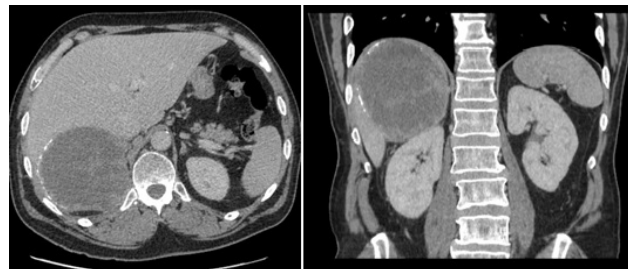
Computed Tomography (CT) scan of the abdomen that identified a 10.6 × 11.4 × 10.9 cm cystic hepatic mass within segments 6-8. There is visible calcification and heterogeneity of the lesion. These did not immediately suggest a cancerous tumor, prompting additional investigation
